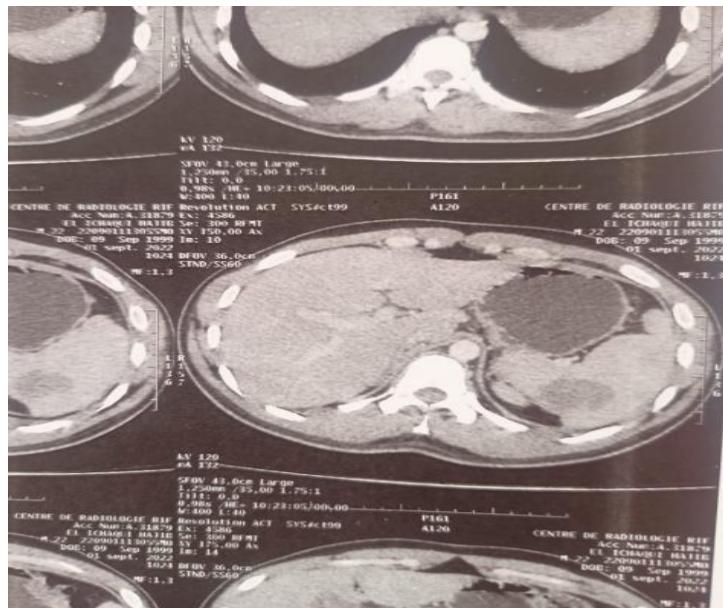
Transverse section of an abdominal CT scan passing through the spleen
